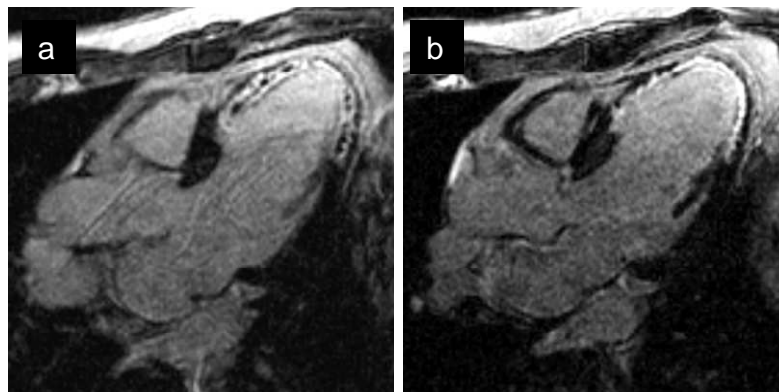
Intramyocardial haemorrhage (white marker) is seen as a central region of low signal within the region of high signal of infarct-related oedema on the T2-weighted spinecho image (a). The corresponding delayed contrast-enhanced image (b) shows a small central hypo-intense region (black marker) corresponding to microvascular obstruction.
